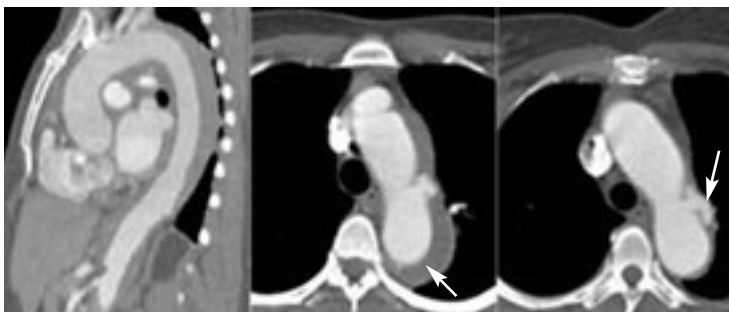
Coronal reformatted image (left) and axial image (middle) from contrast-enhanced, cardiac-gated CT in a patient with an acute type A intramural hematoma and a penetrating ulcer. Note the eccentric increased attenuation in the lateral aspect of the aortic arch representing the hematoma (arrow, middle panel) and the contrast-filled outpouching laterally representing the penetrating ulcer. Follow-up imaging several months later (right) shows that the intramural hematoma resolved although the penetrating ulcer persisted (arrow, right panel).
